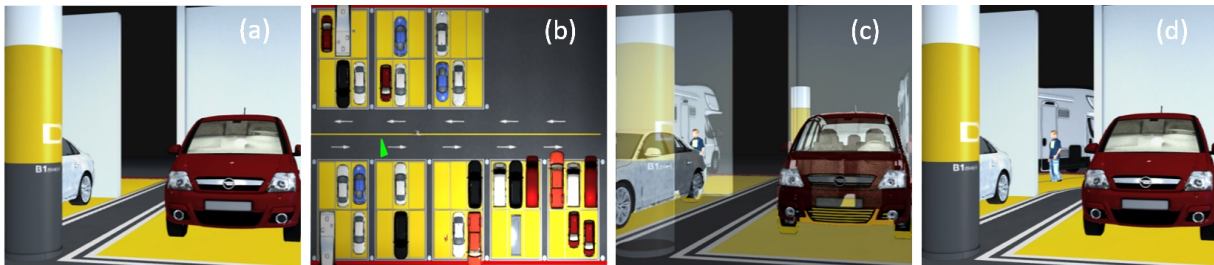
The task of finding a person in a garage, using conventional visualization (a), top view visualization (b), X-ray visualization (c), and multiperspective visualization (d).
